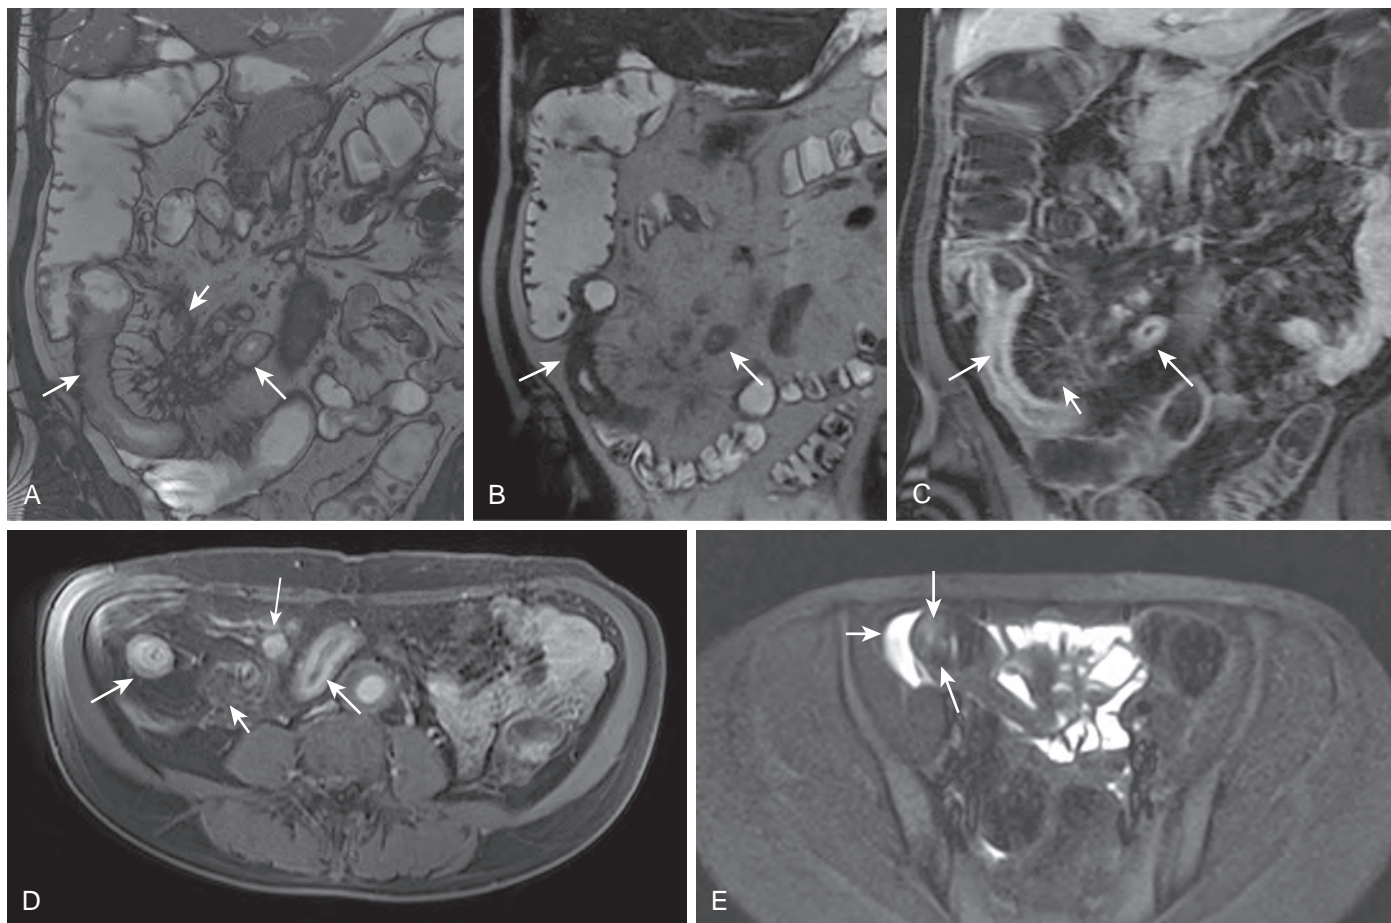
MR enterography in 48-year-old man with active Crohn's disease. A. Coronal true FISP image shows extensive fibrofatty proliferation of mesentery (*short arrow*) associated with diseased ileal loops (*long arrows*). B. Coronal half-Fourier RARE sequence shows diseased ileal loops (*arrows*) but provides poor information concerning the mesentery. Coronal (C) and axial (D) contrast-enhanced fat-saturated T1-weighted VIBE images show stratified contrast enhancement with avid enhancement of mucosa relative to submucosal and muscular layers (*long arrow*) and layered appearance. Note the high signal intensity linear structure caused by increased vascularity (*short arrows*) close to the mesenteric border of the small bowel segment involved, the so-called comb sign and inflamed mesenteric nodes (*small arrow* in D). E. T2-weighted fat sat image shows increased signal intensity of the thickened wall, indicative of submucosal edema (*arrows*) with small fluid collection.
